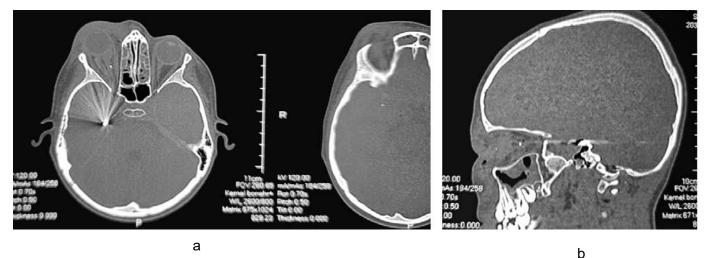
Axial (a) and sagittal (b) head computed tomography. Note multiple foreign bodies in the right orbit, right frontal basal lobe, and right temporal basal lobes of the brain
